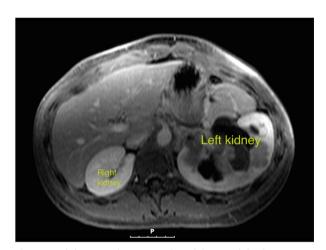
Abdominopelvic MRI with gadolinium slide showing left renal mass with hydronephrosis and infiltration of the renal artery
